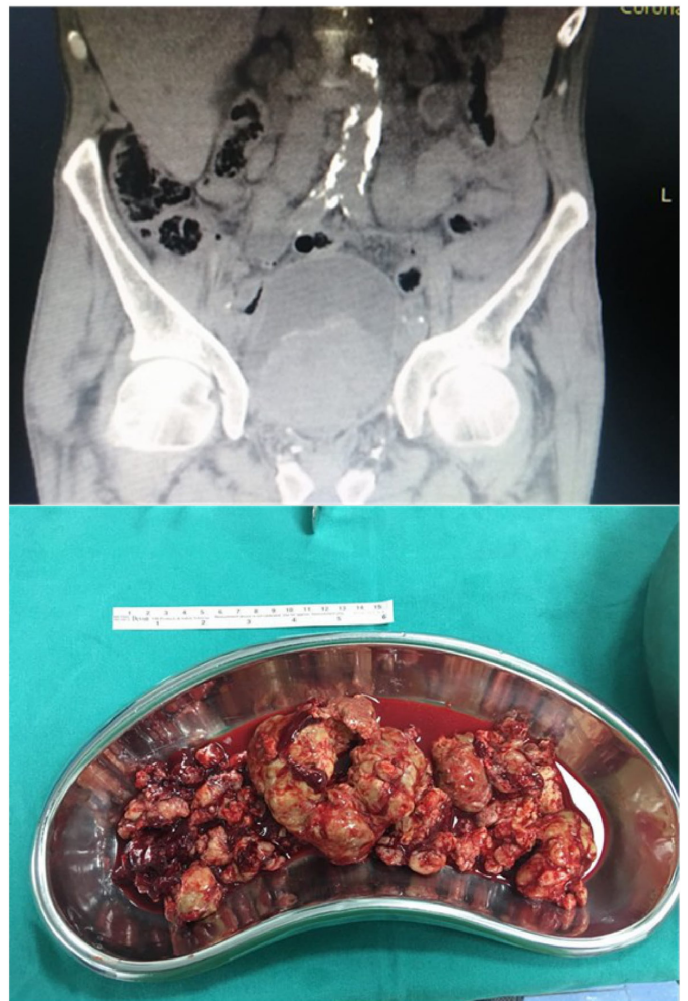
Magnetic resonance imaging of the mass, 2b. Removed mass, 2c. Anti-cytokeratin positivity in atypical cells (AE1/AE3, Genemed, USA; 1/50×20)
